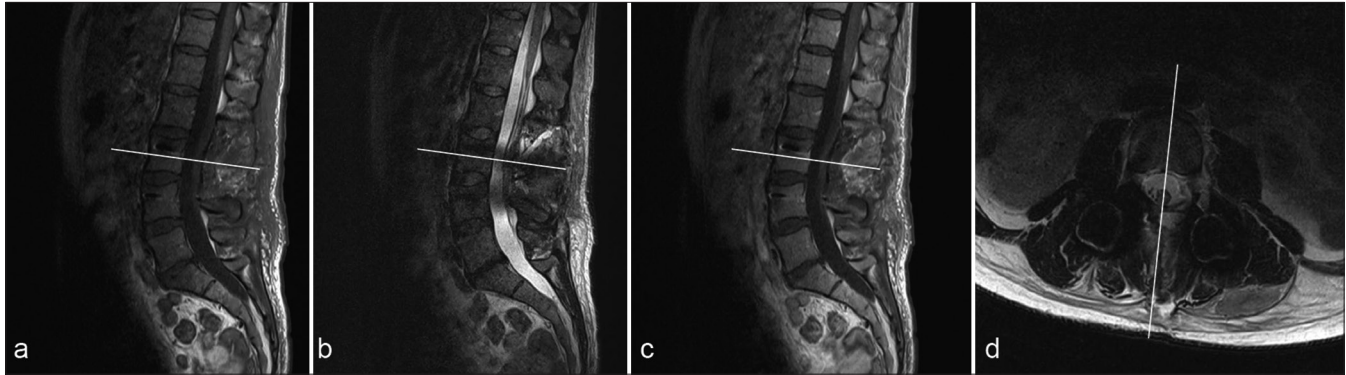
Postoperative magnetic resonance images. (a-d) Sagittal T1-weighted, sagittal and axial T2-weighted, and sagittal contrast-enhanced T1-weighted images show no residual lesion. Figures a-c are at the level of the white line in Figure d. Figure d is at the level of the white line in Figures a-c.
